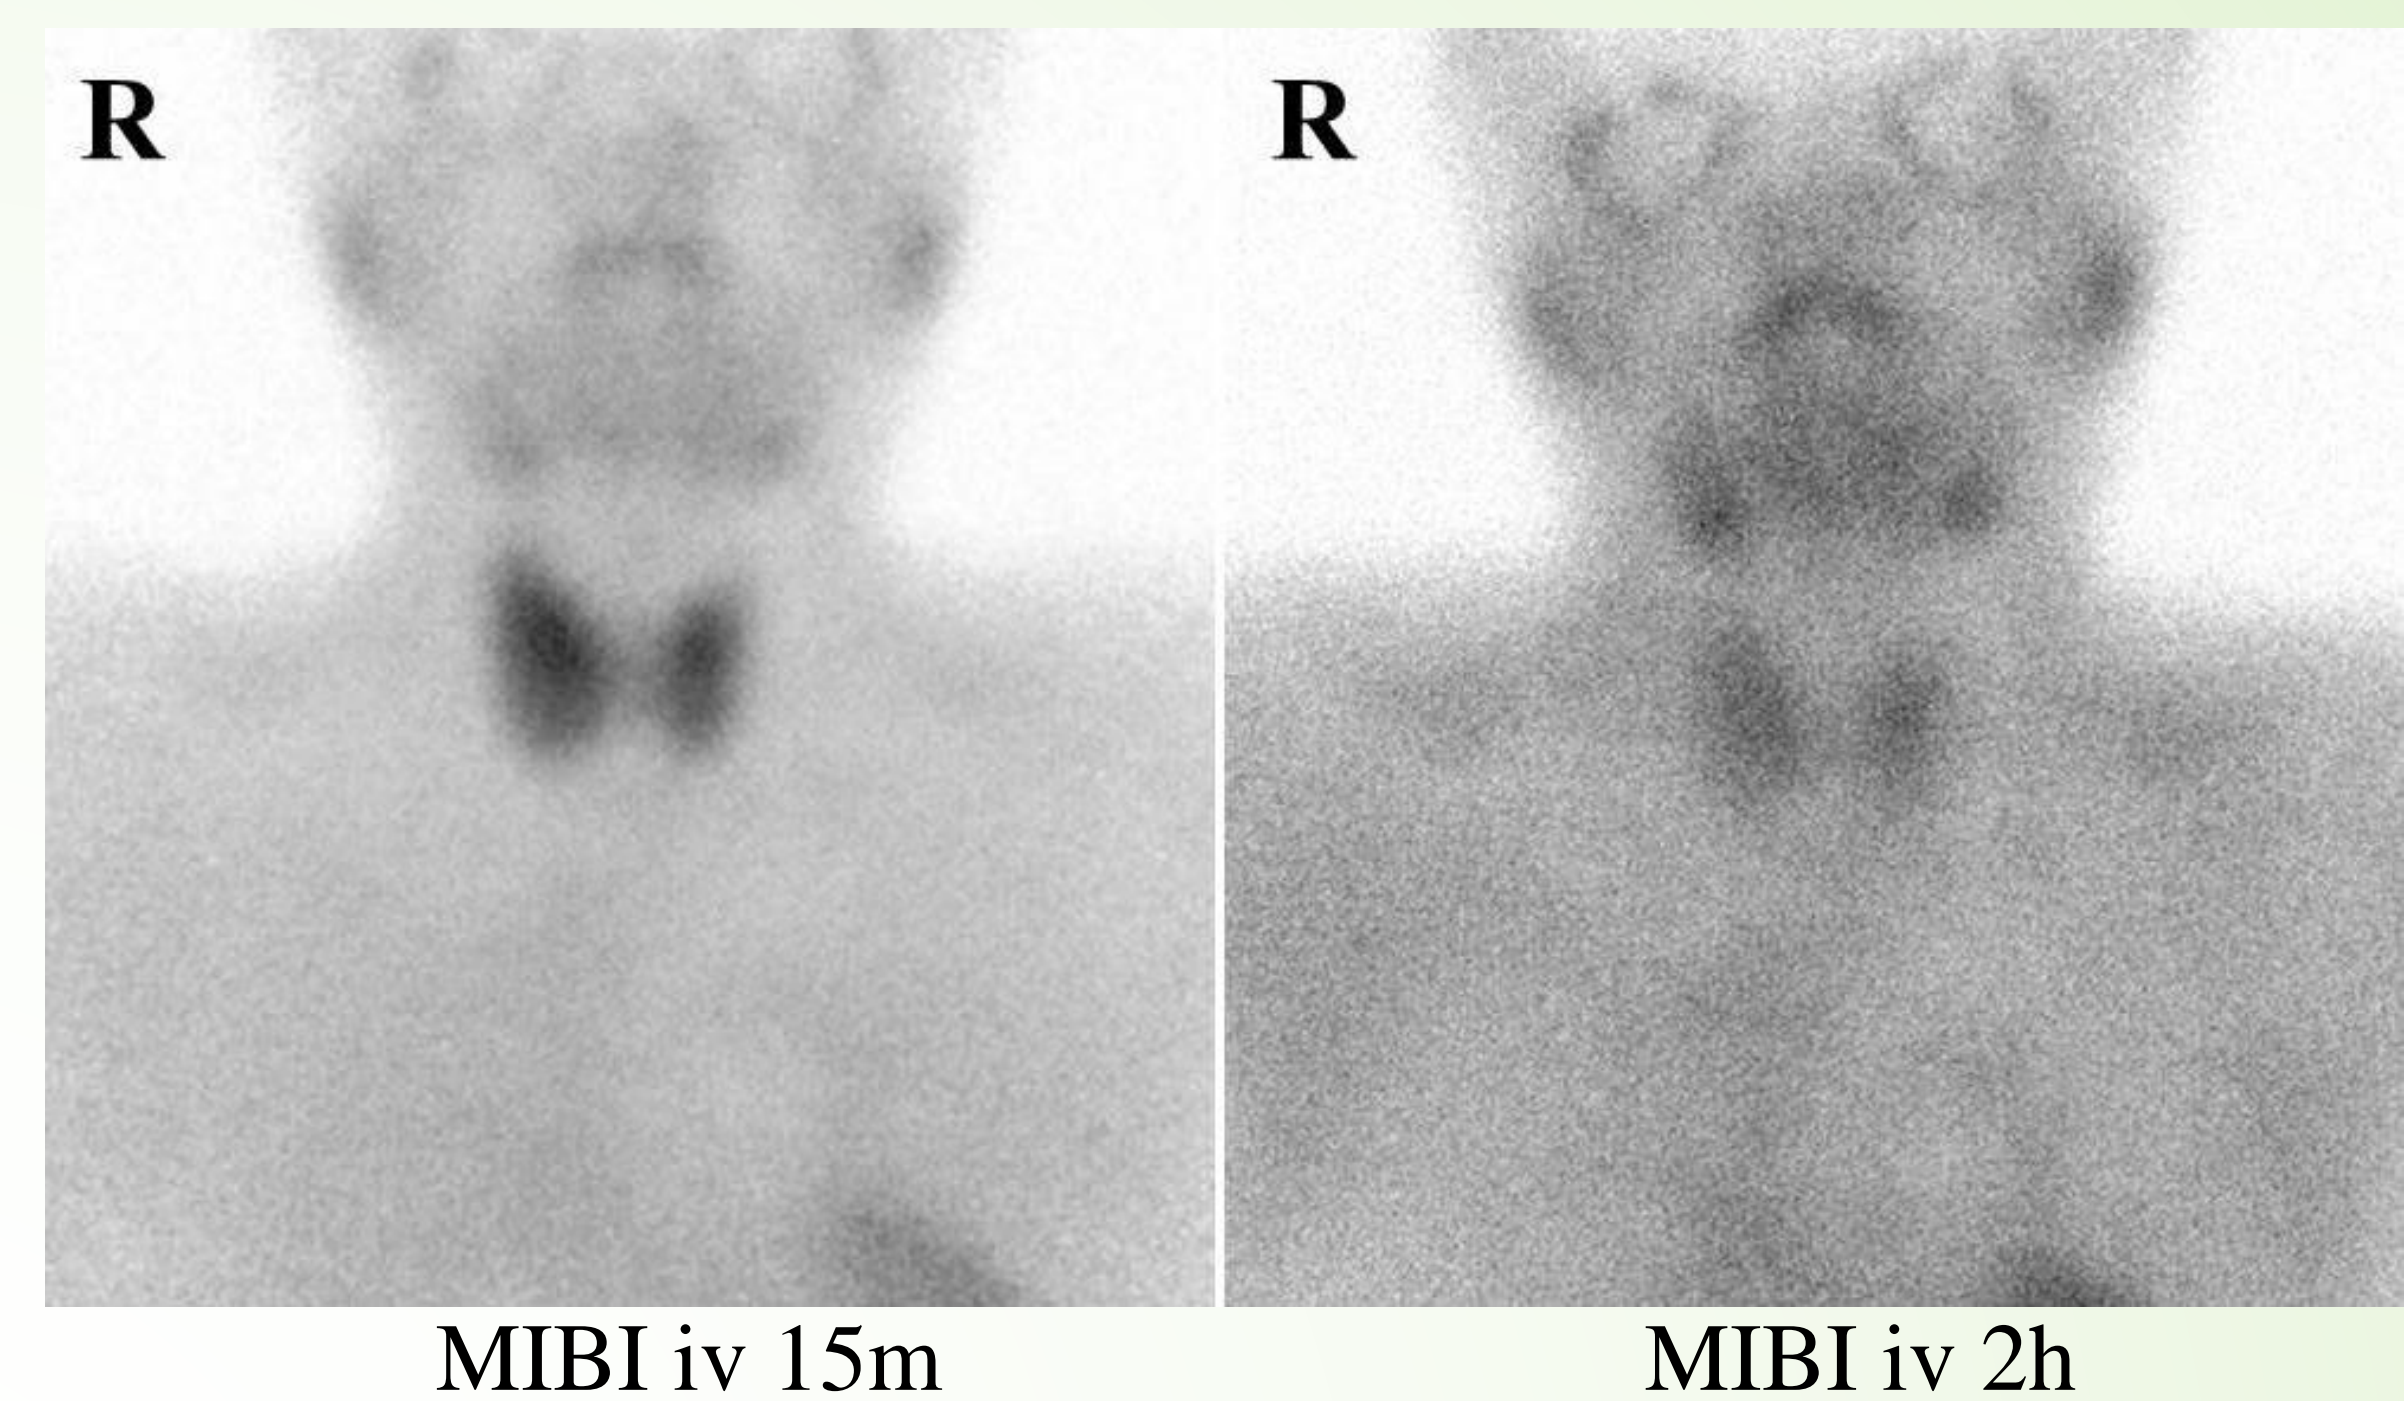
MIBI scintigraphy showed slight accumulation in the upper left parathyroid gland at 2 hours compared to 15 minutes after administration of technetium – 99m MIBI.
